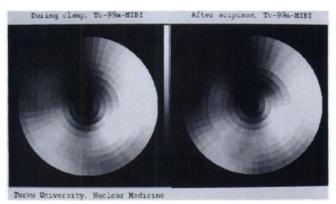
An example of polar tomograms of SPECT perfusion studies at rest. A similar tracer distribution was obtained during both approaches.
